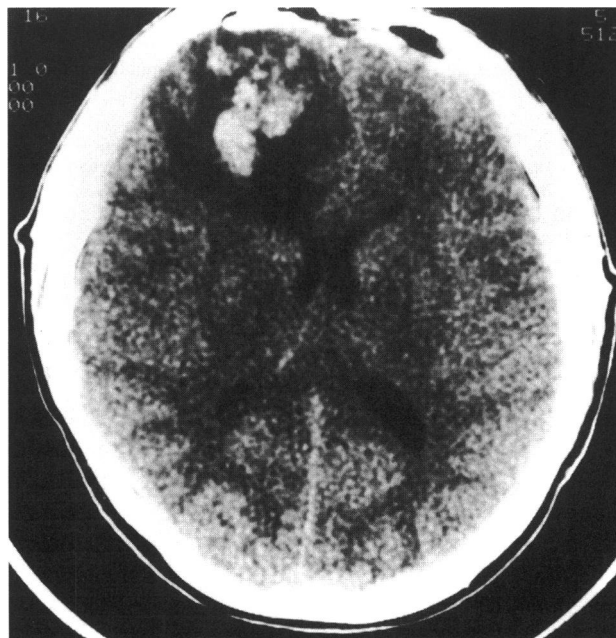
Axial CT scan demonstrating a frontal lobe intracerebral retraction hematoma which occurred after anterior craniofacial resection of an aggressive fibrosarcoma.
